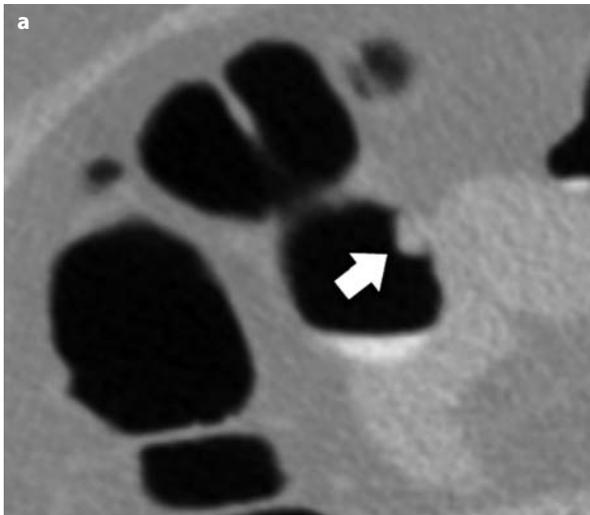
a, b. Visualization of an 8-mm tubulovillous adenoma (arrow) with 2D (a) and 3D (b) evaluation at CT colonography with the patient in the supine position
